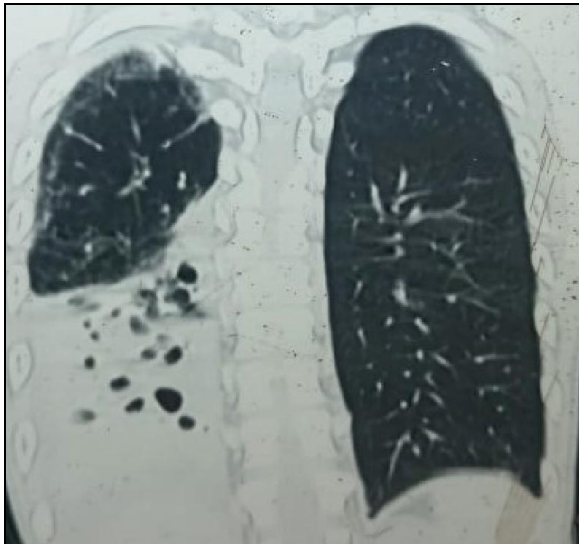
CT scan chest – pre operatively
